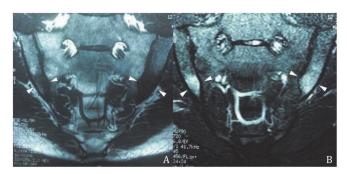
Magnetic resonance imaging demonstrating bilateral sacroiliitis (white arrowhead) on T1-weighted (A) and T-2 weighted (B) axial views.
